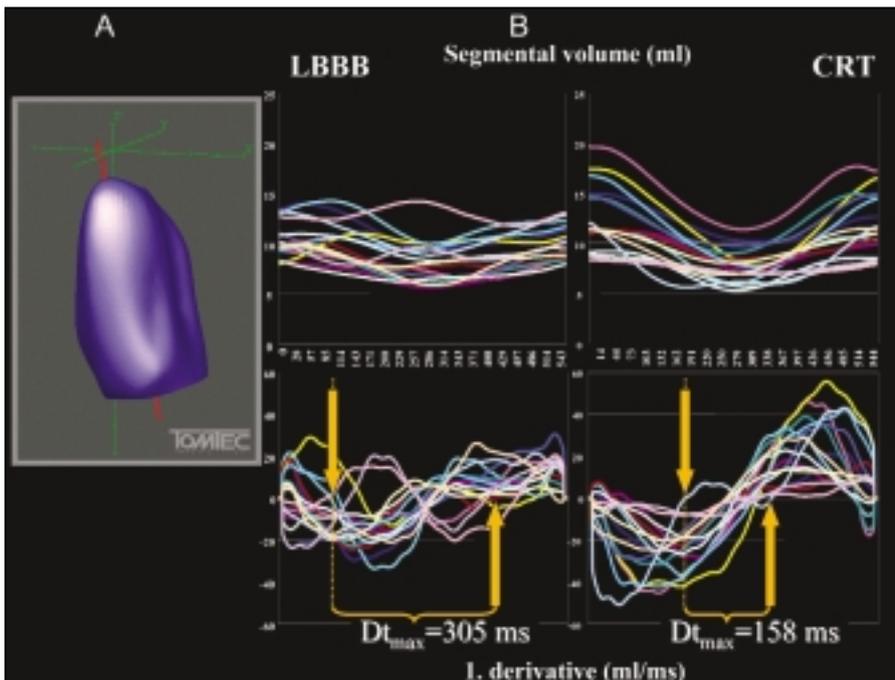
Quantitative analysis of regional left ventricular volumes in patients treated with cardiac resynchronization therapy (CRT) using real-time 3D echocardiography. 3D data were analyzed off-line using a semi-automated contour tracing algorithm (LV Analysis 1.2RT, TomTec) over a complete heart cycle. A shows reconstructed LV cavity. B shows temporal volume changes of LV segments in systole and diastole with colors representing different LV segments before and after cardiac resynchronization therapy (CRT). Upper panels show the segmental volume-time curves (color coded for all 16 segments) during left bundle branch block (LBBB) and during reprogramming of the pacer with biventricular pacing. The bottom panels show the first mathematical derivative, which aids in the identification of the segmental local systolic minimum of the segmental volume (crossing point between curve and x-axis). The time from beginning of QRS (0 on the x axis) to the segmental minimum of each segment is called T. A mean of all 16 Ts, a standard deviation (SD-Ts) and a maximal intersegmental delay (Dtmax) was calculated. The last two parameters seem to be capable of estimating the degree of asynchrony. Both decrease significantly from LBBB to CRT. The arrows point to the very first and the very last segment reaching a local volume minimum. Time difference between these points is then Dtmax. Image courtesy TomTec Imaging Systems and Andreas Franke, MD.
